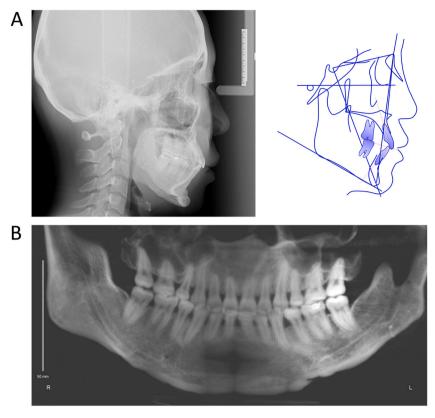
(A) Post-treatment lateral cephalogram and cephalometric tracing. (B) Post-treatment panoramic radiograph.
